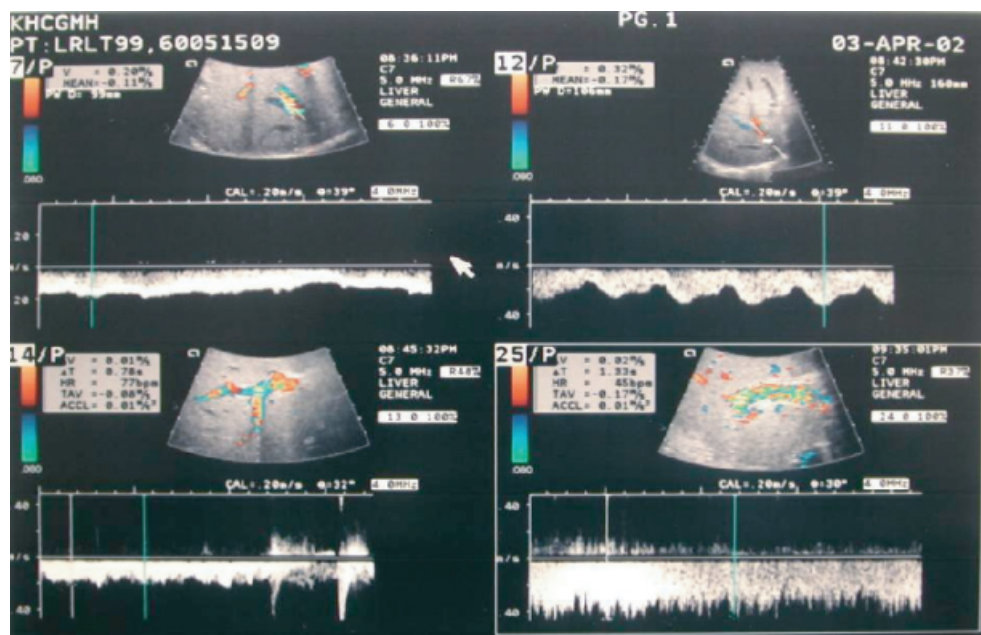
Use of Doppler ultrasound in detecting obstruction and velocities.
